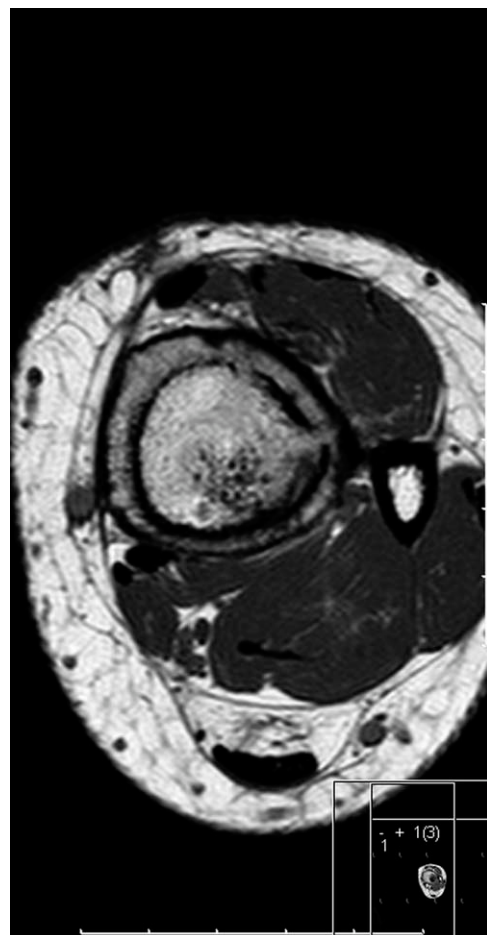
Long-term follow-up axial CT of nonossified fibroma in the distal tibia treated with BG, showing a thickened cortex with “double cortex” formation (arrow).
